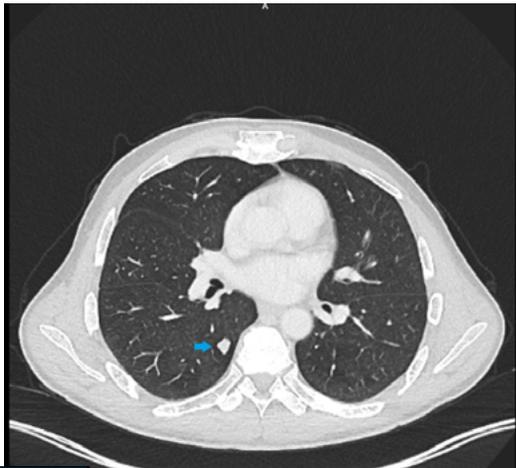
A solitary pulmonary nodule that suspected ectopic focus for Cushing syndrome is seen at the right lower lobe on thorax CT.*
